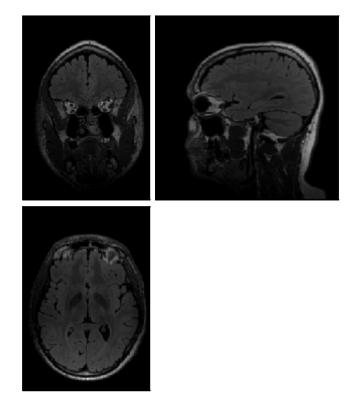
Coronal (top, left), sagittal (top, right) and axial (bottom) sections of the pre-MRI of a representative patient in SPM8.
